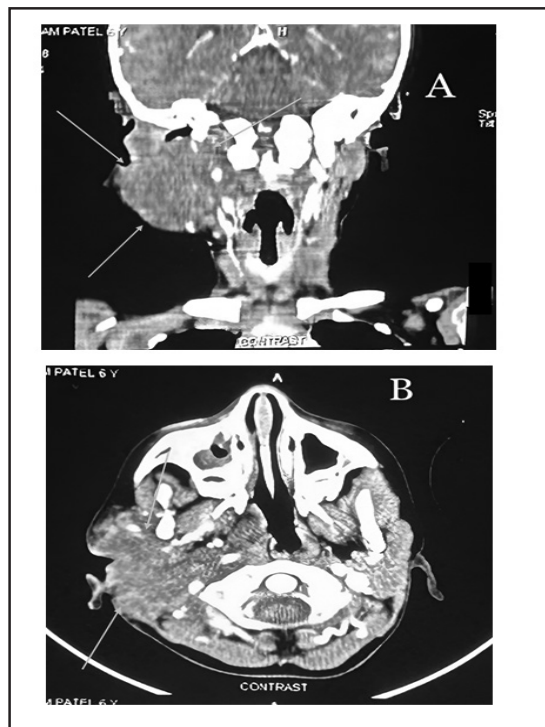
Contrast enhanced computed tomography scan coronal (A) and axial (B) cut - ill-defined heterogeneously enhancing mass arising in the Rparotid gland without any bony involvement or intracranial extension, anteriorly extending in the masticator space; posteriorly till the right stercleidomastoid; lateral to right external auditory canal; medially reaching till the right parapharyngeal space.(as depicted via the arrows in yellow).
